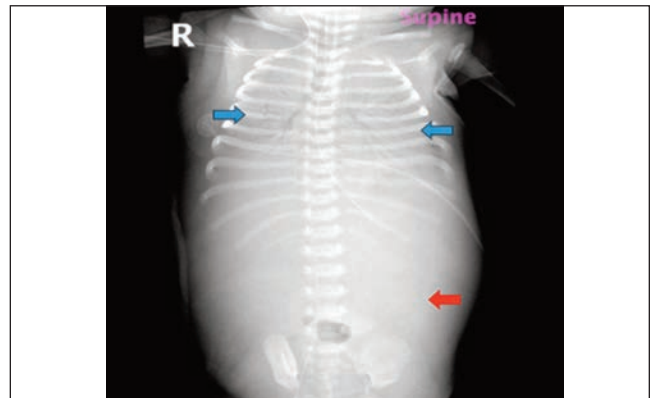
X-ray image of the chest and abdomen showing complete opacification of both lung fields, suggesting pulmonary haemorrhage (blue arrows). Paucity of air in the bowel loops is noted with generalised haze of the abdomen, due to ascites (red arrow).
